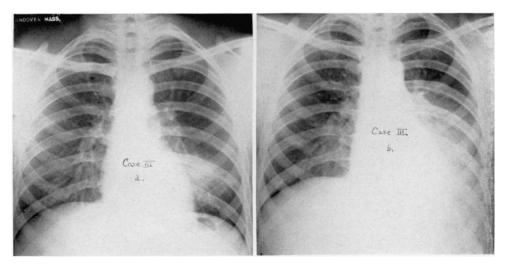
(Case III). X-rays showing the development of a lesion at the base, rather than from the hilum. a. X-ray taken on the third day of the disease. b. X-ray taken on the eighth day of the disease.
